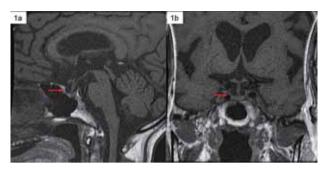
Sagittal(1a) and coronal(1b) T1-weighted MRI of pituitary demonstrate an apparent empty sella with cerebrospinal fluid filling in the sella turcica, pituitary stalk remaining in the midline, and the pituitary gland flattened against sellar floor.
